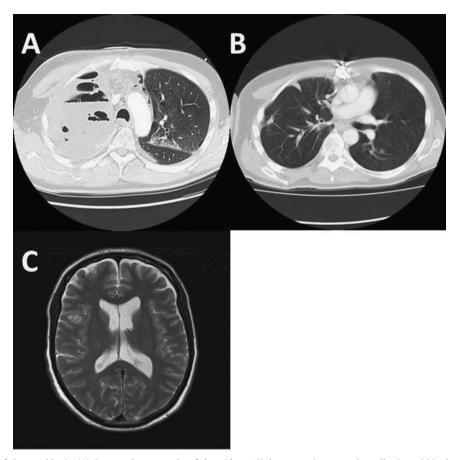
Radiographic images of chest and brain. (A) Computed tomography of chest (day +16) demonstrating a massive collection within the right hemithorax comprising solid and fluid components and multiple gas locules. There is extension to the retrosternal region without bony erosion or destruction. (B) Computed tomography of chest (day +108) demonstrating 8 mm pulmonary nodule in left lower lobe and resolution of previous right hemithorax changes. (C) Magnetic resonance imaging of brain (day +284), T2-weighted signal, demonstrating right frontotemporal lobe ring-enhancing lesion with some surrounding oedema at the grey-white matter interface.
